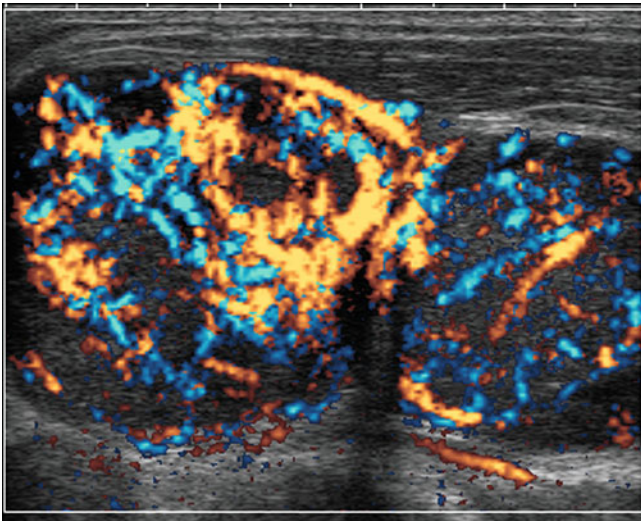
Metastatic lymph nodes of the supraclavicular region. Intense, peripheral vascularization using directional power Doppler imaging for two adjacent lymph nodes
